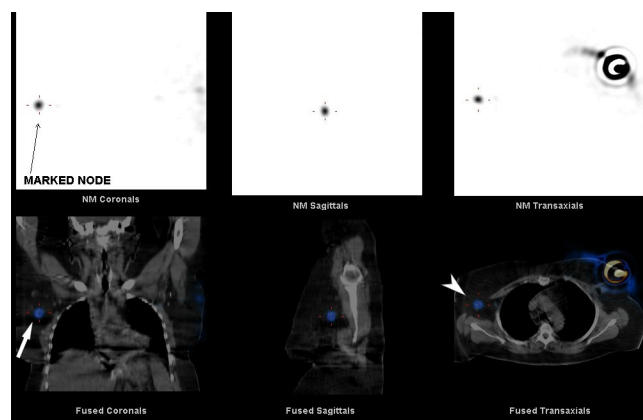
Fused lymphoscintigraphy image showing radiotracer uptake in the right axilla. Black arrow shows radiotracer uptake. White arrow in coronal image demonstrates radiotracer uptake in contralateral (right) sentinel lymph node. White arrowhead in axial image demonstrates uptake in the right axilla. NM, nuclear medicine.
